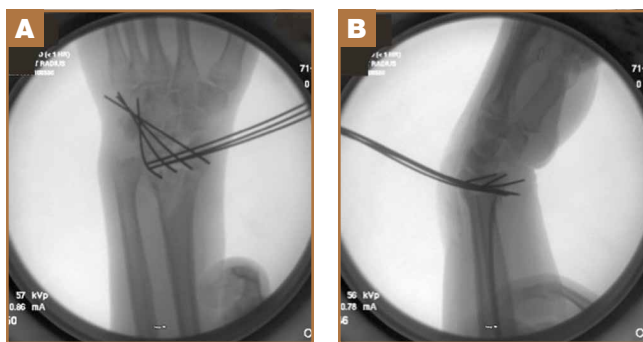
(A) Anteroposterior and (B) lateral radiographs show reduction of comminuted articular surface en bloc into near anatomical position.
